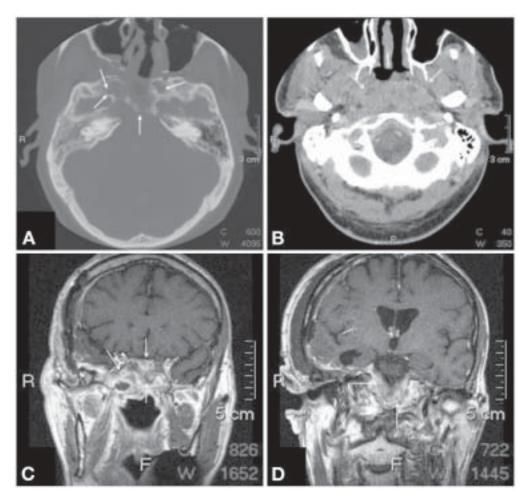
Neuroimaging of a patient with null-cell pituitary carcinoma (same patient as Fig. 2). The patient underwent two surgical resections (1994, 2000) and sellar radiation therapy before these images. (A) Bone windows of CT scan through the skull base demonstrate marked erosion involving the sphenoid bone and petrous apices (arrows) [data of procedure (DOP) 06/2001]. (B) Contrastenhanced CT through the nasopharynx shows extremely enlarged bilateral metastatic retropharyngeal lymph nodes (arrows) with central necrosis [DOP 12/2002]. (C,D). Coronal gadolinium-enhanced T1-weighted MRI images reveal an inhomogeneously enhancing infiltrating mass involving the sella turcica, sphenoid sinus, nasopharyngeal soft tissues, and clivus (arrows) [DOP 05/2005].
